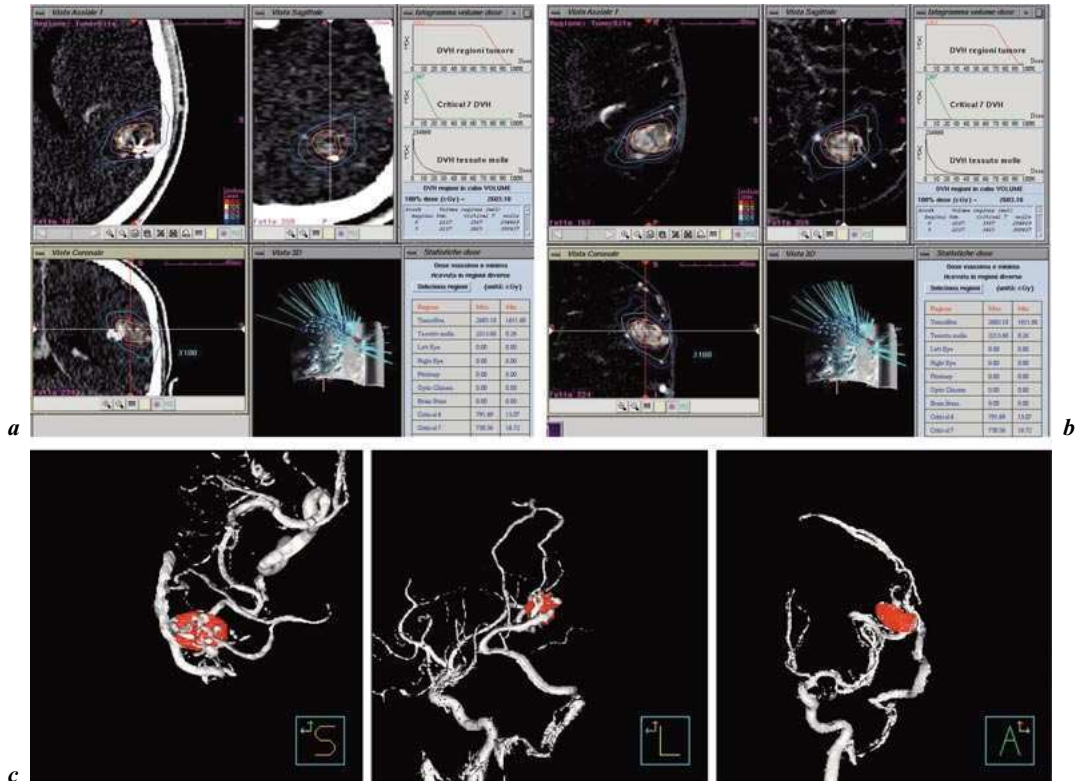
C.G., 40-years-old male. Epilepsy due to a left temporal AVM fed by middle cerebral branches. Target volume 2.7 ml. Conformal treatment planning, collimator 10 mm, 26Gy Dmax. a Treatment planning on Cyberknife console, displaying isodoses lines on a CT, (b) 3DRA on axial, sagittal and frontal plane and (c) 3DRA reconstructed images, showing the AVM nidus, treatment target volume, covered by 70% isodose surface.
